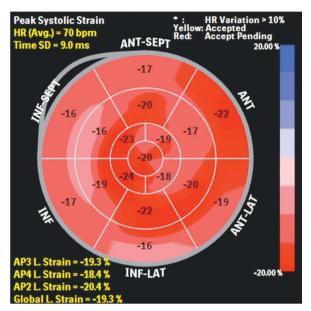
2D-strain echocardiography displays longitudinal strain of each left ventricular segment on bull's eye map.
